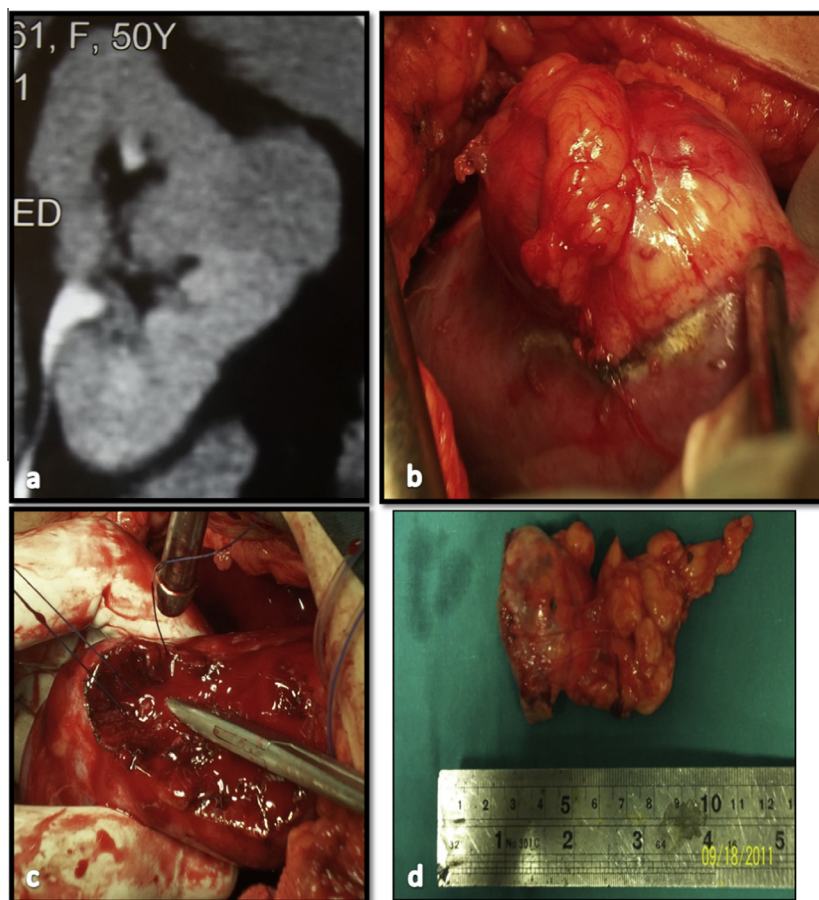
Coronal CT image of a right renal midzonal exophytic renal mass (a) and the corresponding intraoperative pictures before (b) and after (c) wedge resection of the mass. Picture of the mass after resection (d).
